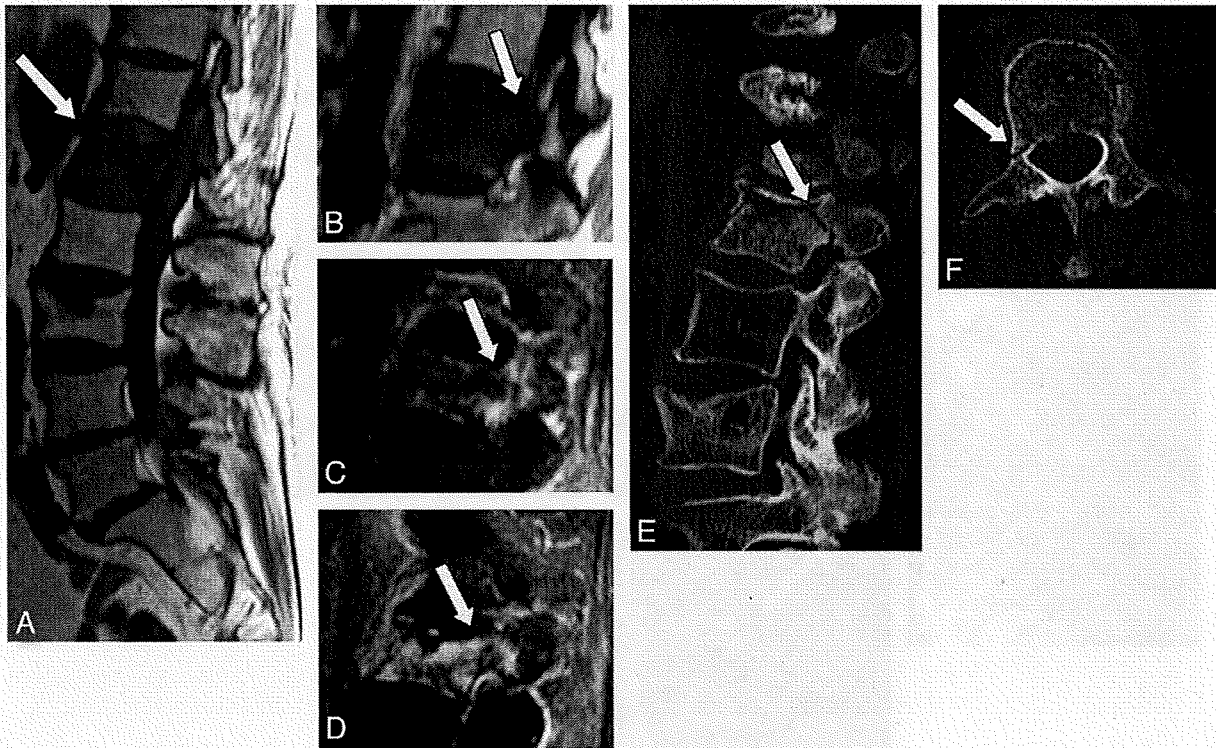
A 79-year-old woman with benign compression fracture which occurred one-and-a-half months earlier. *A* and *B*, T1WI shows diffuse hypointensity in the vertebral body and the right pedicle of L1 (arrow). *C*, STIR image shows heterogeneous hyperintensity in these areas (arrow). *D*, Contrast-enhanced T1WI shows marked enhancement (arrow). *E* and *F*, On sagittal (*E*) and axial (*F*) CT scans, fracture is seen in the right pedicle (arrow), which is a presumable reason for the abnormal signal intensity on MR imaging.
